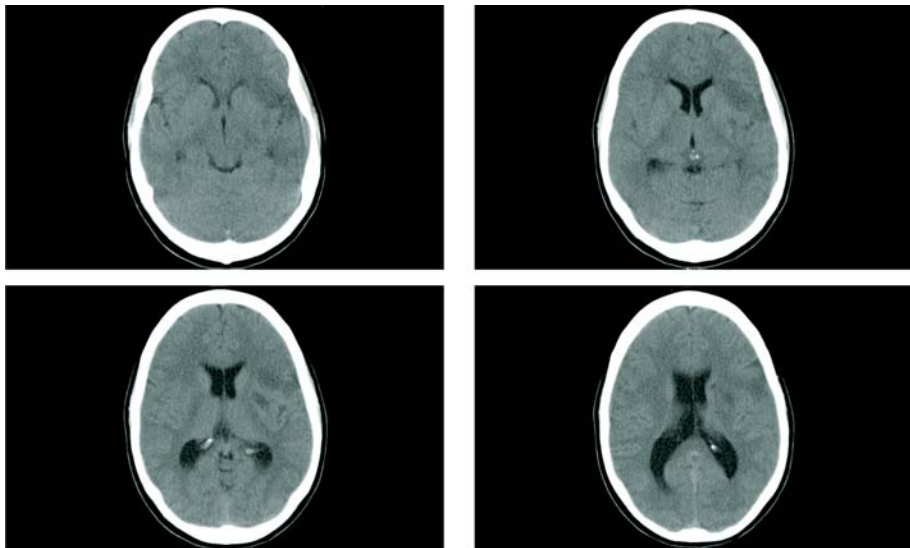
Same patient 7 days after stroke; clinically slight disturbance of coordination right hand no motor deficit, no aphasia. CT shows disseminated necrosis in all regions where earlier permeability was observed (left striatum, frontal cortex and medulla).
